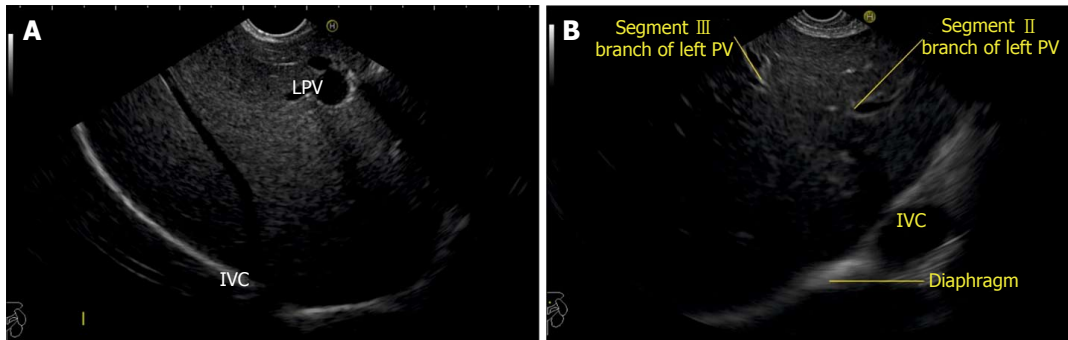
Endoscopic ultrasound from descending duodenum. A: Figure showing right hepatic vein; B: On anticlockwise rotation from 2nd part of duodenum, the inferior vena cava gradually moves from 9 o'clock position towards 4 o'clock position. LPV: Left portal vein; PV: Portal vein; IVC: Inferior vena cava.
